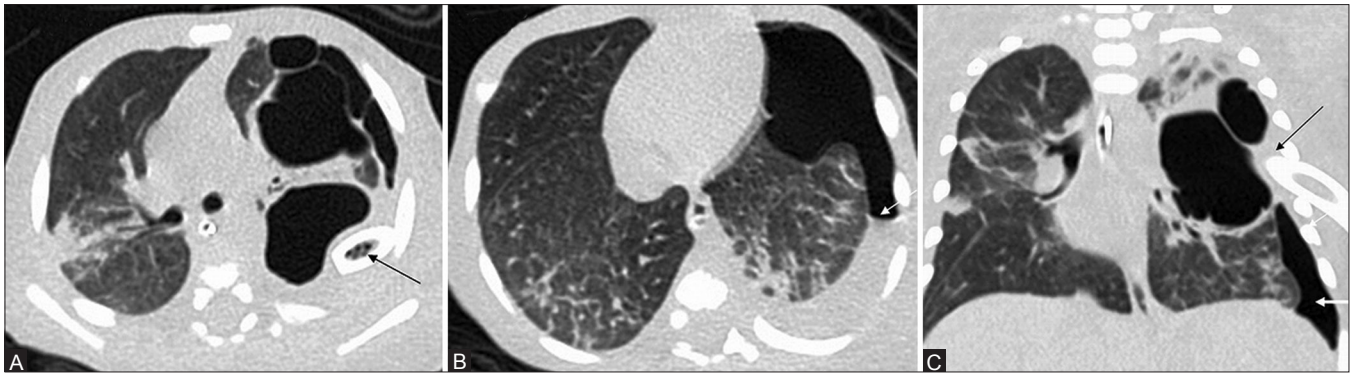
(A-C): CT chest lung window axial sections show (A) chest tube insertion (black arrow) in a multiseptated cystic lesion in the right upper lobe, (B) resulting in the formation of hydropneumothorax (white arrow). (C) Coronal image shows the chest tube (black arrow) in the multicystic lesion and the resultant pneumothorax (white arrow). Diagnosis was confirmed after surgery as type 1 CCAM
